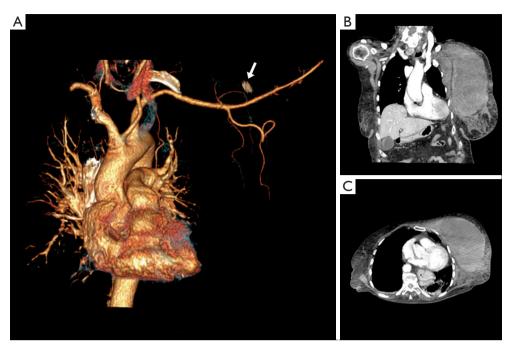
Radiological imaging studies. (A) Patient 1. Angiography study with active bleeding at the level of the collateral branch of the left subclavian artery (arrow). (B,C) Patient 2. Thoracic computed tomography with 18 cm × 16 cm × 9 cm left retropectoral hematoma.
